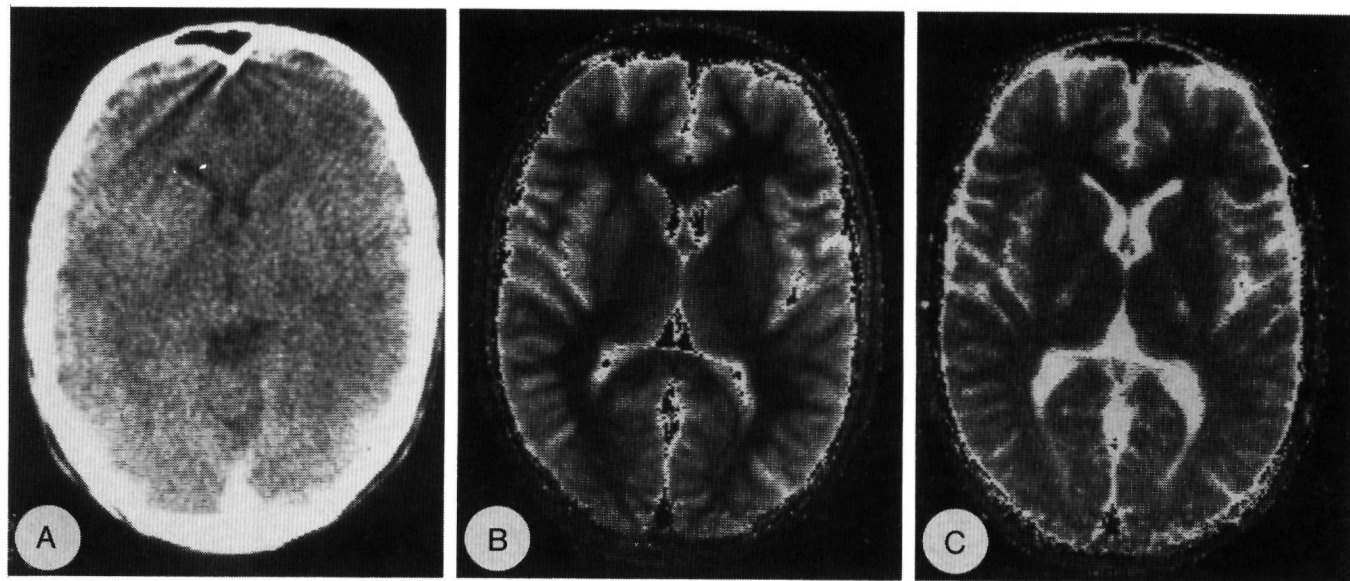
(Case3). A, CT image. Normal densities in the regions of the basal nuclei. B, calculated T_1 image. Normal intensities in the regions of the basal nuclei. C, calculated T_2 image. Hypointensive areas bilaterally in the posterior limb of the internal capsule.
